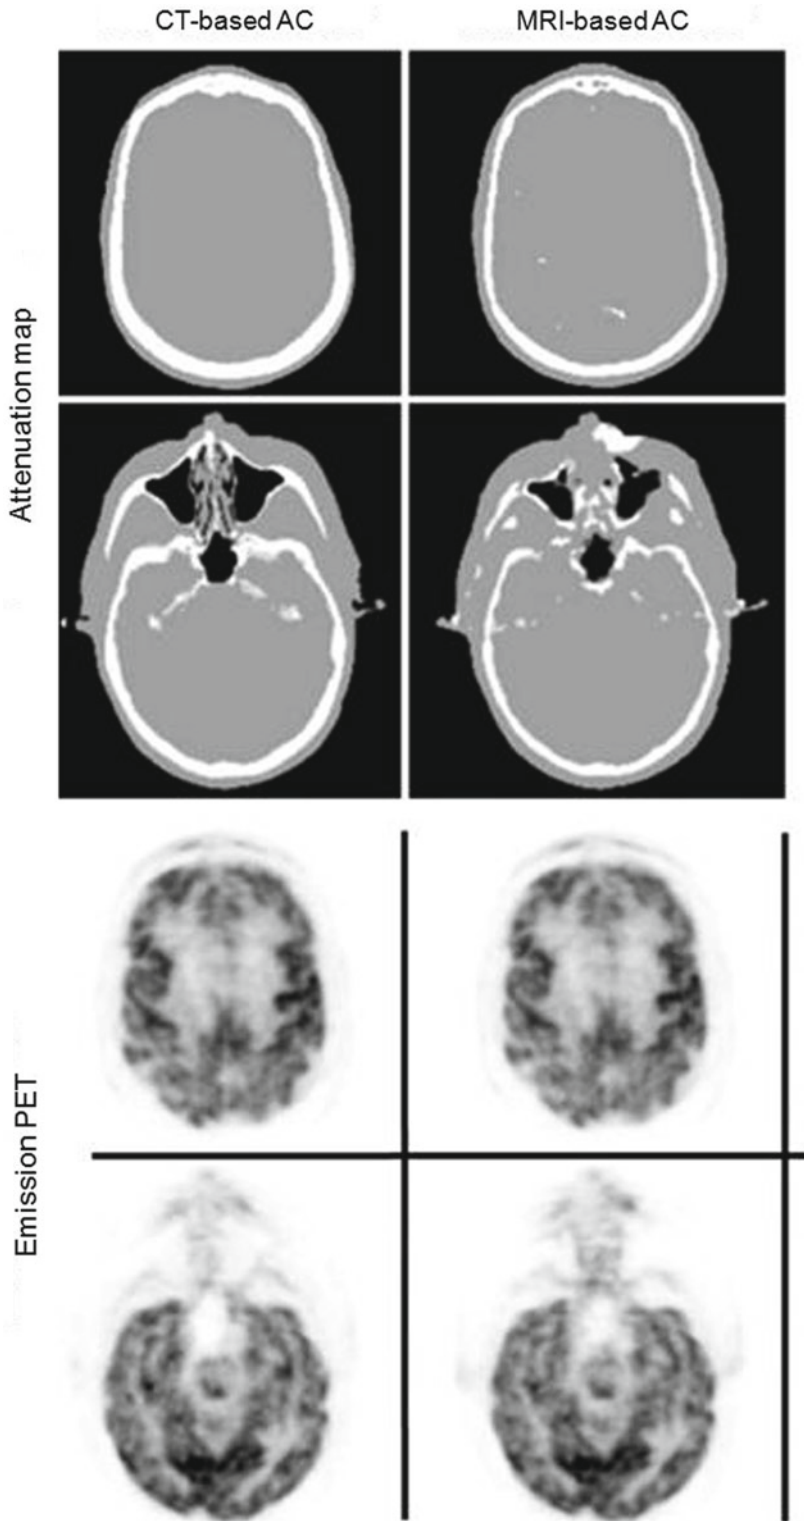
Attenuation correction using MR images acquired using UTE sequence (Reprinted from [23] with permission)
